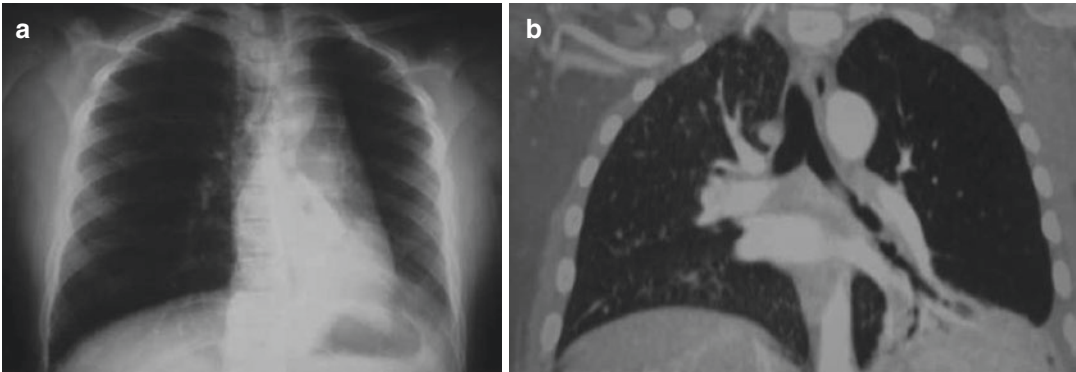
Bronchial sequelae of a foreign body. Anteroposterior chest x-ray of a 5-year-old child presenting with chronic atelectasis in the left inferior lobe (a). Axial CT scan of the chest, showing bronchiectasis in the left lung (b)
